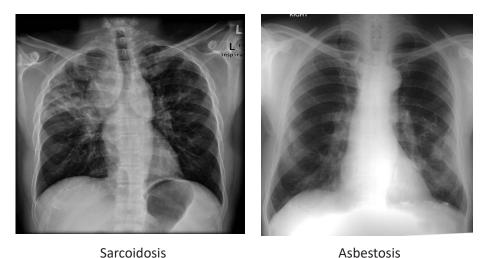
Chest X-Ray presentation of sarcoidosis and asbestosis
